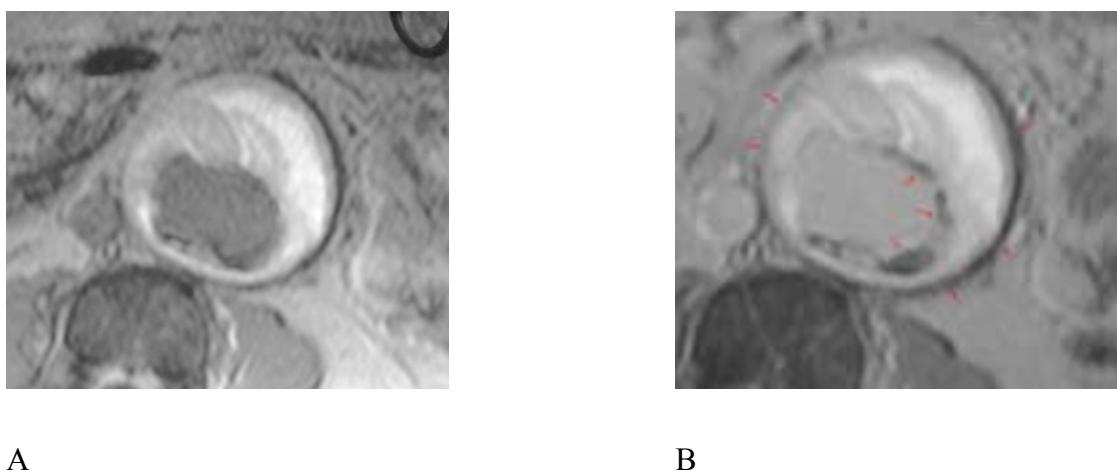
Axial 2D gradient-echo MRI at the level of the infrarenal aneurysmal aorta prior (a) and one hour after (b) SPIO administration. The aortic wall and parietal calcifications are clearly visible (a, arrow). On the postcontrast image, a heterogeneous pronounced signal loss related to SPIO uptake at the level aortic wall is seen (b, arrow).
